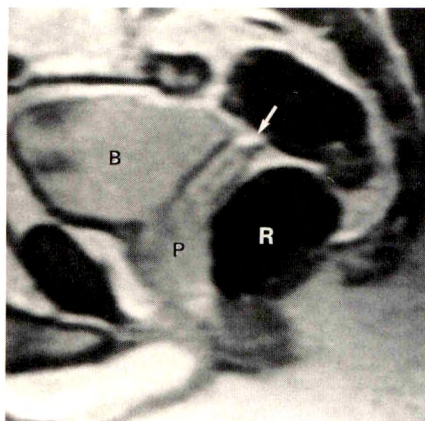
T2-weighted sagittal MR scan of pelvis shows that normal prostate gland (P) abuts mid and distal rectum (R) anteriorly. Note region of peritoneal reflection (arrow) overlying midportion of seminal vesicles. Rectum has been distended with air by rectal catheter. B = bladder.
